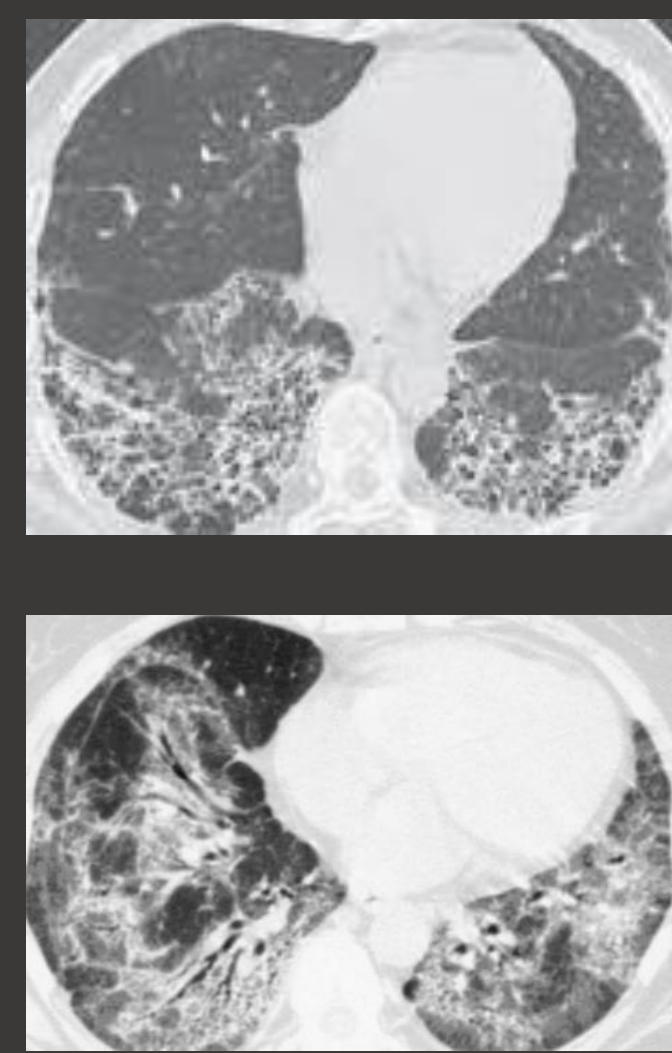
CT consistent with UIP (top) and NSIP (bottom) pattern
